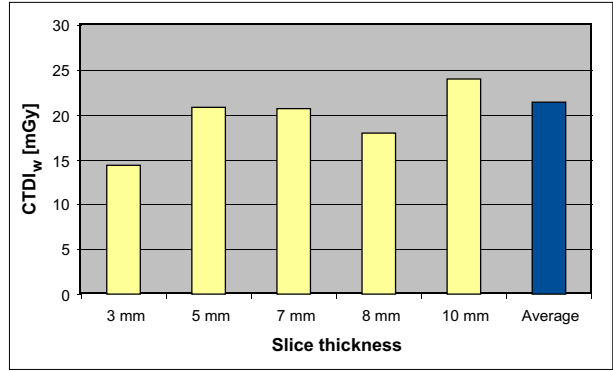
The patient dose (CTDI<sub>w</sub>) for liver examinations, applied by the participants of the German CT survey 1999, was almost constant despite the selection of different slice thicknesses.
